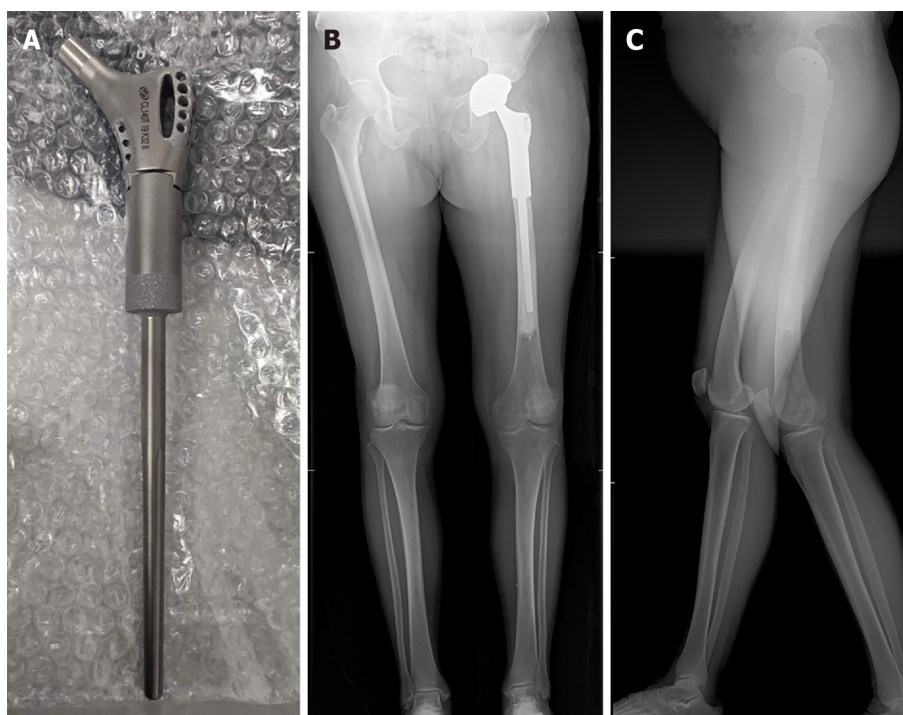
The custom-made prosthesis with porous design, and full lower limb radiographs taken the day after the second-stage revision. A: The custom-made prosthesis with porous design; B: Anteroposterior plane; C: Lateral plane.
